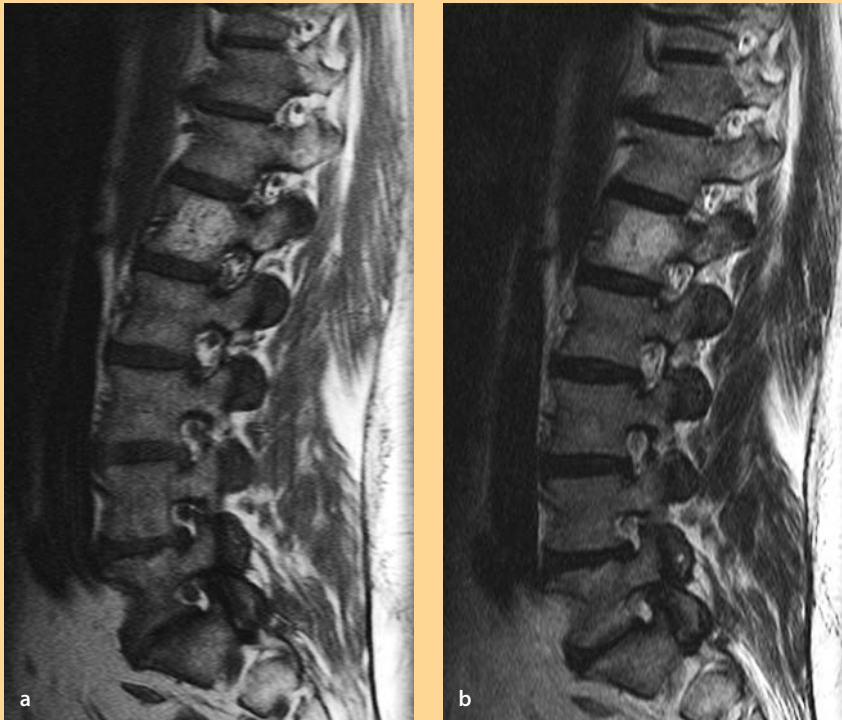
MRI findings of a benign hemangioma
